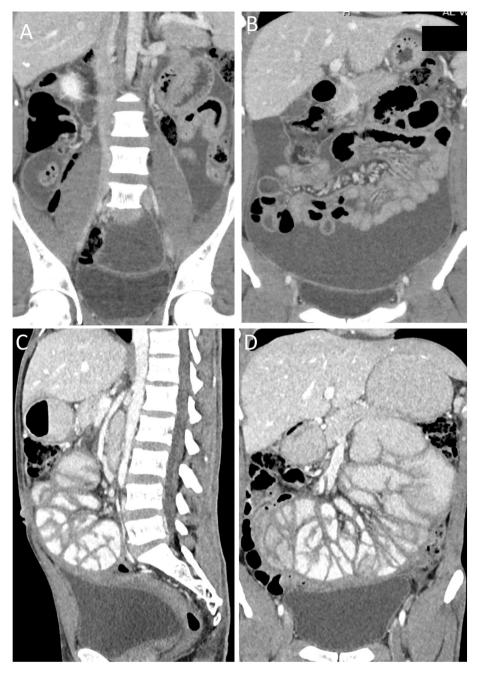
Tuberculous peritonitis. A and B) Contrast-enhanced CT demonstrates diffuse thickening of proximal bowel with matted loops and loculated ascites. C and D) Contrast-enhanced CT 6 months post anti-TB treatment shows a thick enhancing sac-like structure with matted bowel loops in the center of the abdomen and proximal bowel dilation, indicating encapsulating peritoneal sclerosis (abdominal cocoon).
